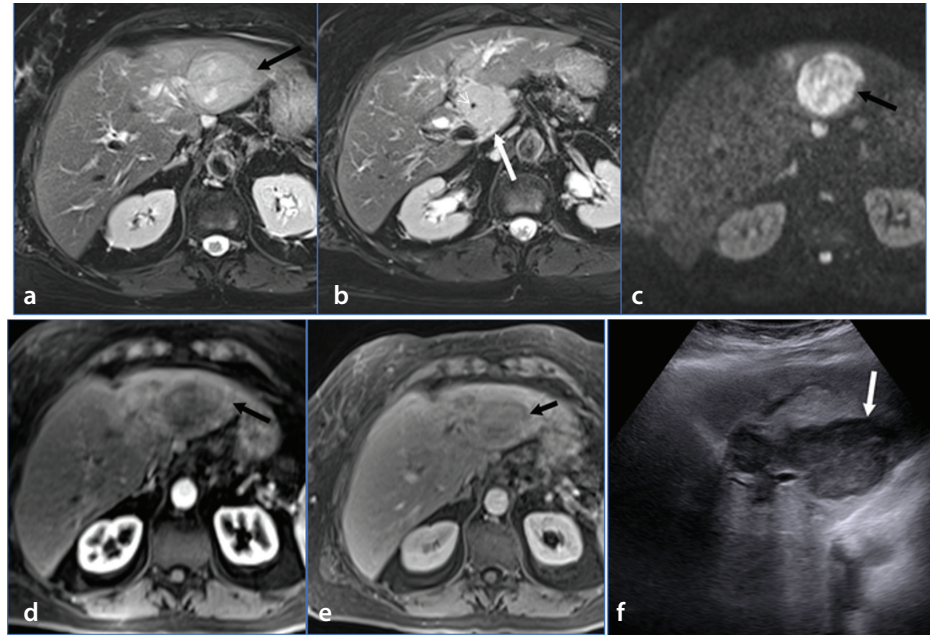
Hepatic lymphoma. Axial T2-weighted imaging (a, b), diffusion-weighted b800 imaging (c), and post-gadolinium T1-weighted imaging with fat suppression during the arterial (d) and delayed (e) phases. There is a well-circumscribed left lobe mass (black arrows) showing heterogeneous increased signal intensity on T2-weighted imaging, diffusion restriction, and poor enhancement following gadolinium administration. The adjacent left lobe demonstrates increased T2 signal intensity due to portal vein compression. A separate mass in the hepatic hilum (long white arrows) shows similar signal and enhancement characteristics. The hilar mass encases the hepatic artery (short white arrow). Transabdominal ultrasonography (f) shows a heterogeneous hypoechoic mass (white arrow).
